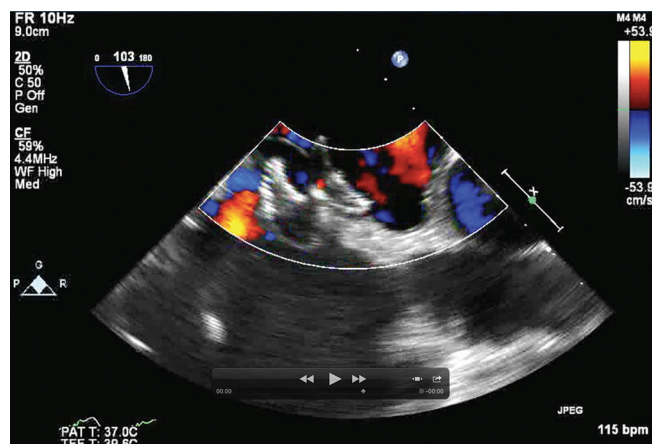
Postoperative closure of patent foramen ovale with amplatzer cribiform device. Bicaval view of transesophageal echocardiography
